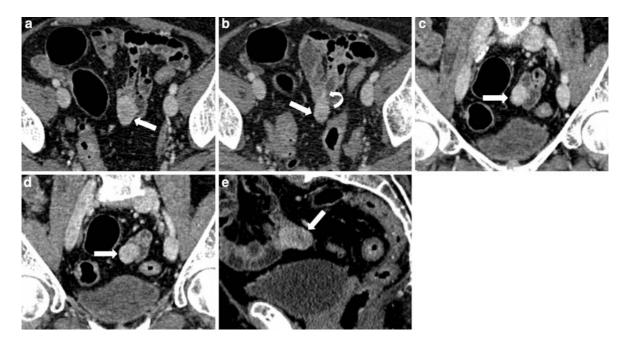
Contrast-enhanced axial (a, b), coronal (c, d) and sagittal (e) CT image showing a well circumscribed hyperenhanced submucosal mass (*arrow*) extending exophytically from small bowel loop and related to GIST. Contrasted enhanced axial CT image shows the presence of a short stalk (*curved arrow*) connecting the exophytic mass to small bowel wall
